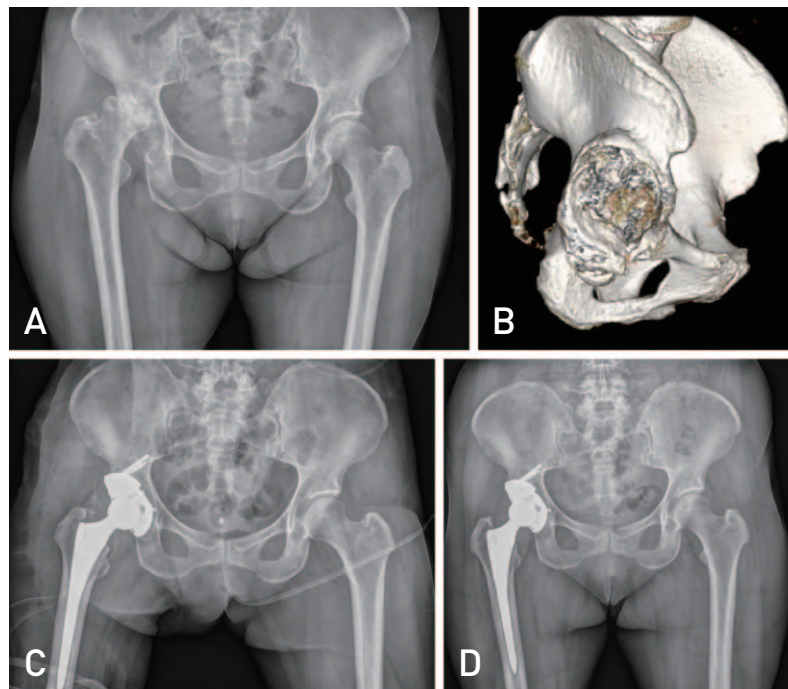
(A) Anteroposterior radiograph shows secondary osteoarthritis due to underlying hip dysplasia. (B) Three-dimensional computed tomography scan shows large bone defect of the acetabulum. (C) Immediate postoperative anteroposterior radiograph. (D) Three years postoperative anteroposterior radiograph shows a well fixed trabecular metal augment and the acetabular cup with bony ingrowth.
